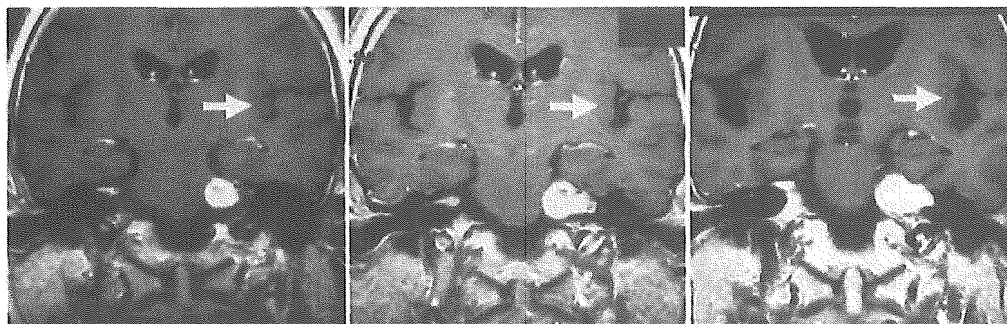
Magnetic resonance images. *Left:* At the initial diagnosis of VS and 41 months before radiotherapy was initiated in a 71-year-old woman, the CSF space appears normal in size and shape. *Center:* At the time of radiotherapy, the CSF space is enlarged. *Right:* Thirteen months later, the patient's communicating hydrocephalus has become symptomatic. Note the gradual dilation of the cisterns and fissures (*arrows*).
